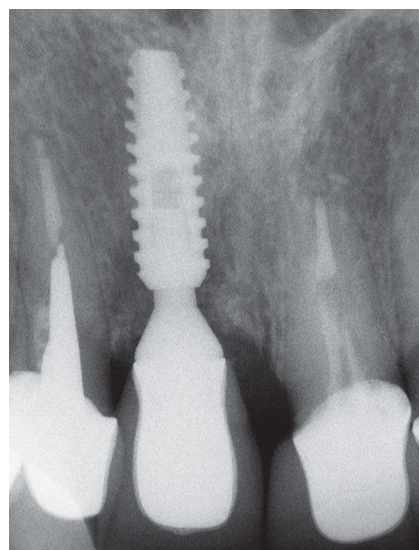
Periapical radiograph after one year.
